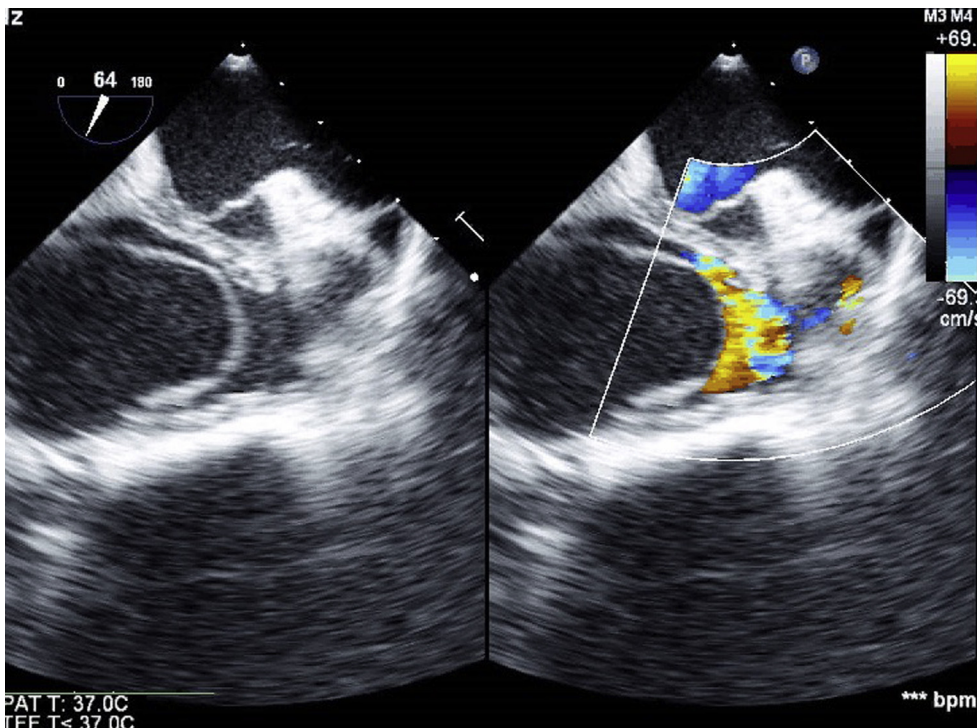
Transesophageal echocardiogram showing the intramural hematoma in the right atrium just above the level of the tricuspid valve interfering with tricuspid inflow.
